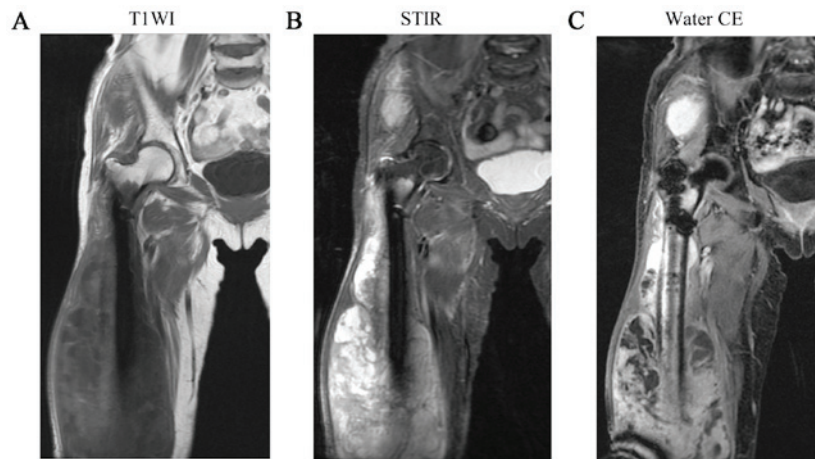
Coronal MRI. MRI demonstrated (A) a low-intensity to iso-intense signal on T1WI images, and (B) a mixed low to high signal intensity on STIR images. (C) Coronal MRI on water selective excitation post-contrast images revealed a mixed low to high signal intensity. Another mass with similar characteristics was found in the right gluteus medius muscle region. MRI, magnetic resonance imaging; T1WI, T1-weighted; STIR, short-T1 inversion recovery; CE, contrast-enhanced.
